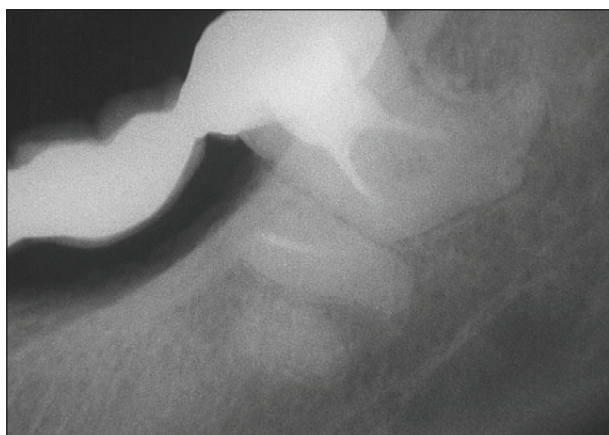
Certain teeth maintain periapical health in spite of insufficient canal obturation.
